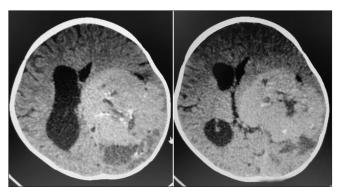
CT brain showing a mass lesion in the left lateral ventricle with surrounding infiltration.
